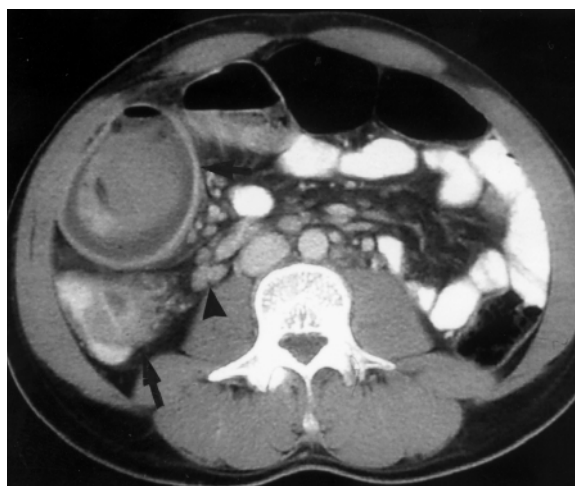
Tuberculosis of colon. A 28-year-old male presenting with fever, abdominal pain, and loose motions of 18 months duration. He had a strong history of contact with an open case of pulmonary tuberculosis. General physical examination was unremarkable. Abdominal examination revealed fullness and vague tender mass in the right iliac fossa. ESR was 10 mm and PPD skin test was 7 mm. Plain X-rays of chest and abdomen were normal. Computed tomography of abdomen with oral and IV contrast shows thickened cecum (*short arrow*), a mass below the cecum (*long arrow*) and 2 lymph nodes of 1 cm diameter each (*arrowhead*). A barium enema (Fig. 37.4a), colonoscopy (Fig. 37.5c), colonic biopsies from the lesion in the cecum (Fig. 37.6b) were performed. Colonic biopsy samples grew *Mycobacterium tuberculosis* on culture. He made rapid clinical improvement with antituberculous treatment
